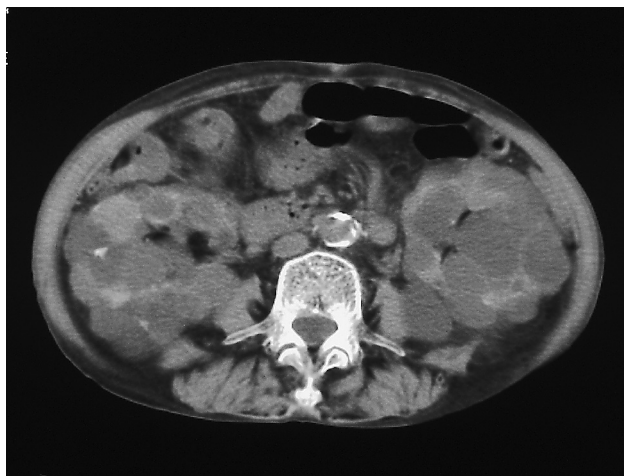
A CT scan obtained at 17 months after TAE shows a marked decrease in the volume of both kidneys.
